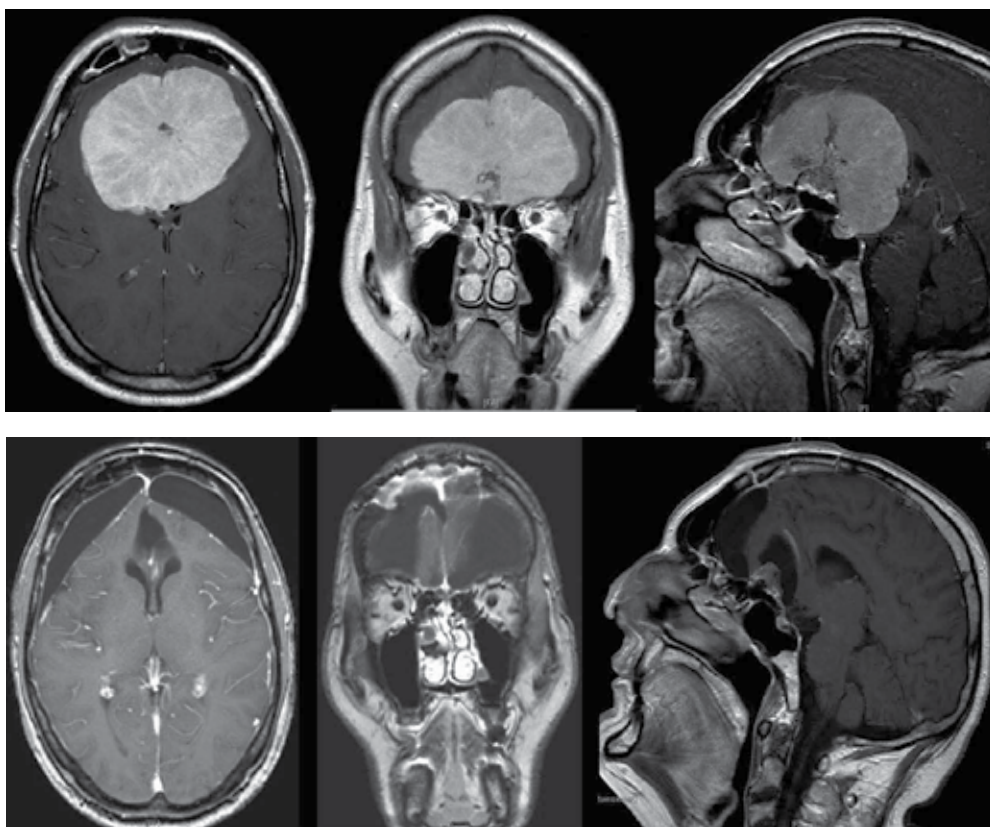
Tri-planar, T1-weighted magnetic resonance imaging after gadolinium application, revealing nearly complete tumour removal (panel below) of the huge tuberculum sellae meningioma.
